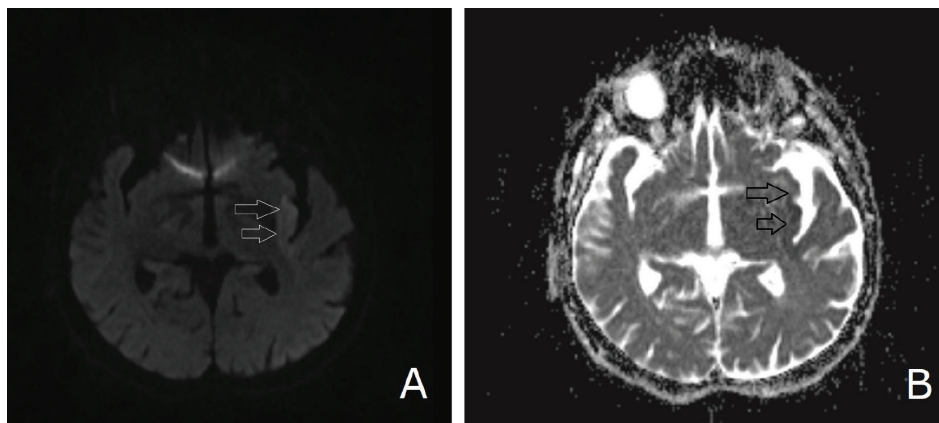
A) Brain diffusion-weighted magnetic resonance imaging: Hyperintensity in the localization of left insular cortex, B) brain apparent diffusion coefficient magnetic resonance imaging: hypointensity in the same location
